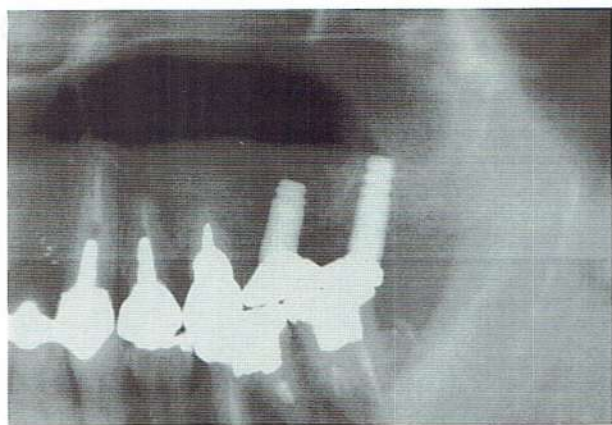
Radiograph at prosthetic structure placement showing no new bone formation on left first molar
